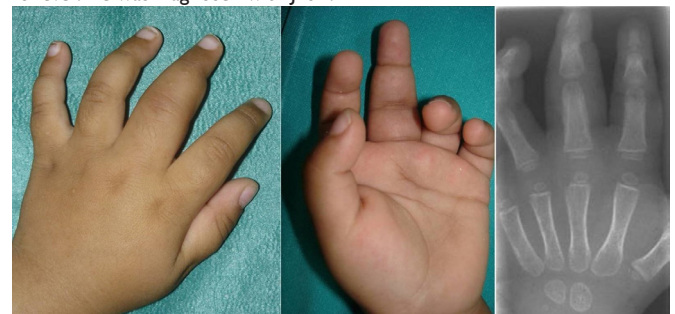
A 2-year-old girl presented with a four-month history of diffuse swelling and restricted movement of the left middle finger. She was afebrile and showed no systemic symptoms. Radiographs revealed periostitis of the proximal phalanx, and laboratory results were normal except for a positive antinuclear antibody titer of 1:320. Knee involvement developed after one month.
